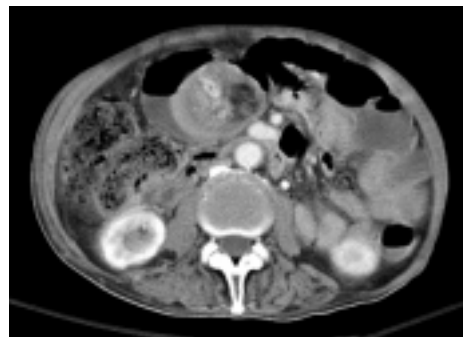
Axial abdominal CT scan.
